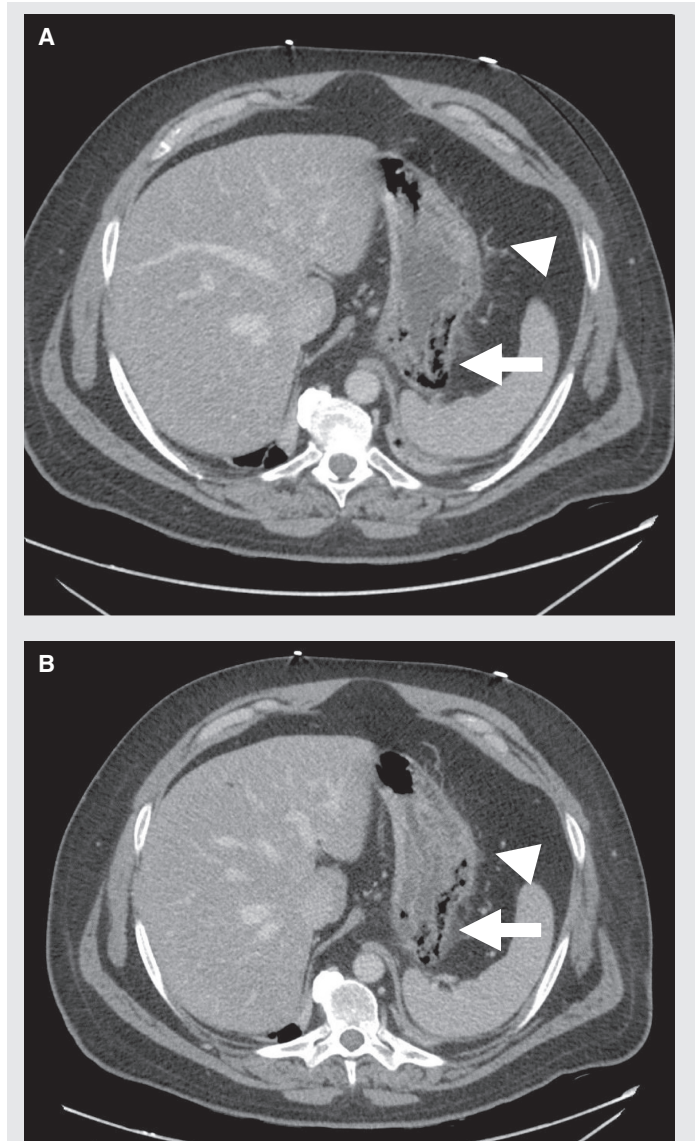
Axial computed tomographic images of the abdomen and pelvis with contrast show intramural gas in the gastric fundus and greater curvature (arrow) consistent with emphysematous gastritis. Pointer showing mild perigastric inflammatory fat stranding.
